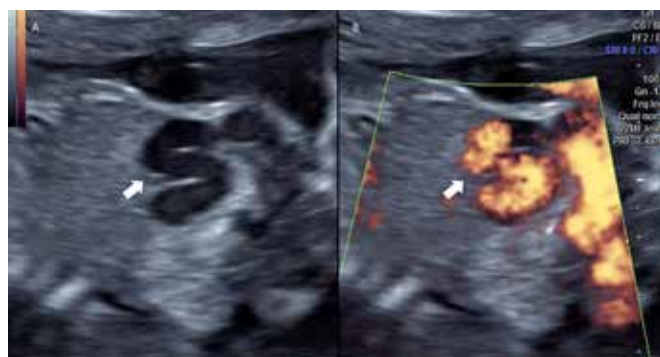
In the image, the thick arrow represents the intra-abdominal, tortuous, dilated umbilical vein, draining into the right iliac vein. B-mode detail on the left (A) and Power Doppler (B) on the right.
